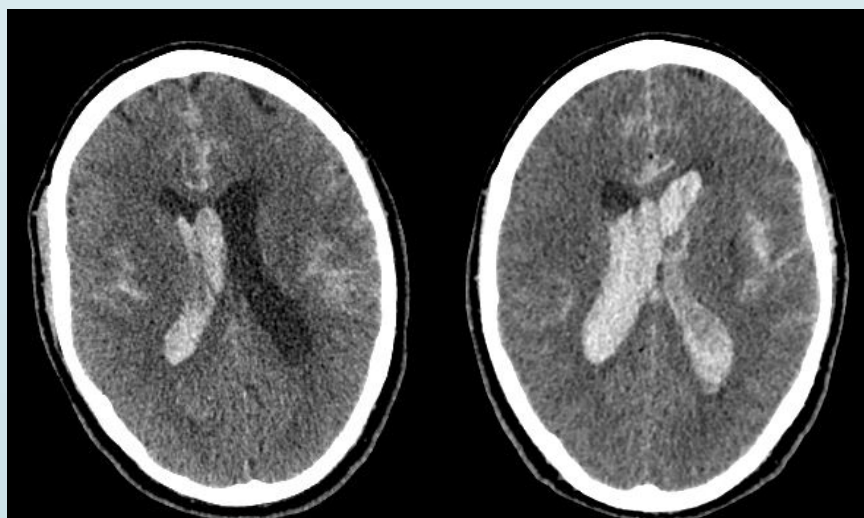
CT head scan of this patient showing a progressing subarachnoid haemorrhage at day1 (left) and day 2 (right)
